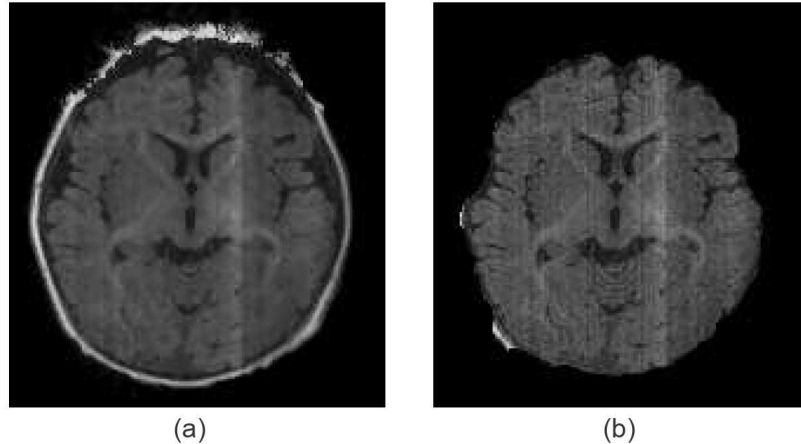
Results of applying the BET algorithm to a bias corrected MRI scan.
